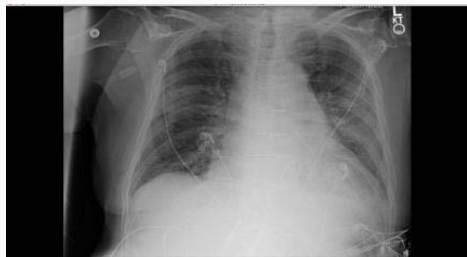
Chest radiograph demonstrating post-operative changes with bilateral infiltrates and a left pleural effusion.
